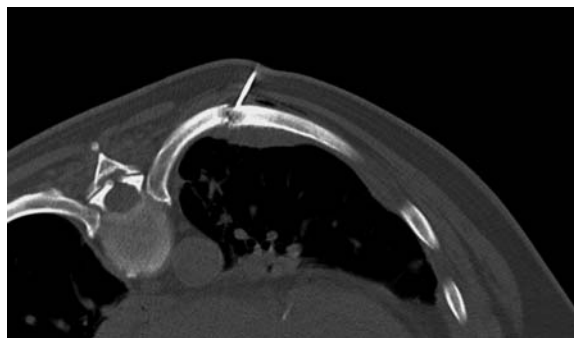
CT-guided percutaneous radiofrequency ablation of a rib metastasis with an associated pathologic fracture causing significant pain
